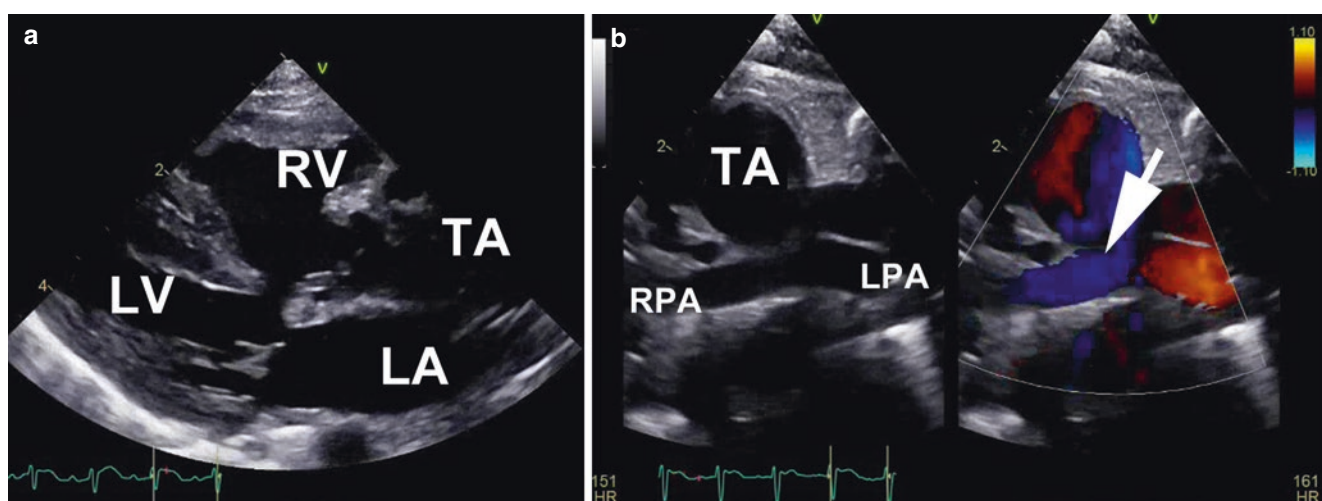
Transthoracic echocardiographic images in a neonate with truncus arteriosus displaying the biventricular origin of the single arterial root in a parasternal long-axis view (panel a). This is a type II truncus arteriosus with normal caliber pulmonary arteries, arising separately from the left posterior aspect of the common trunk as shown by
